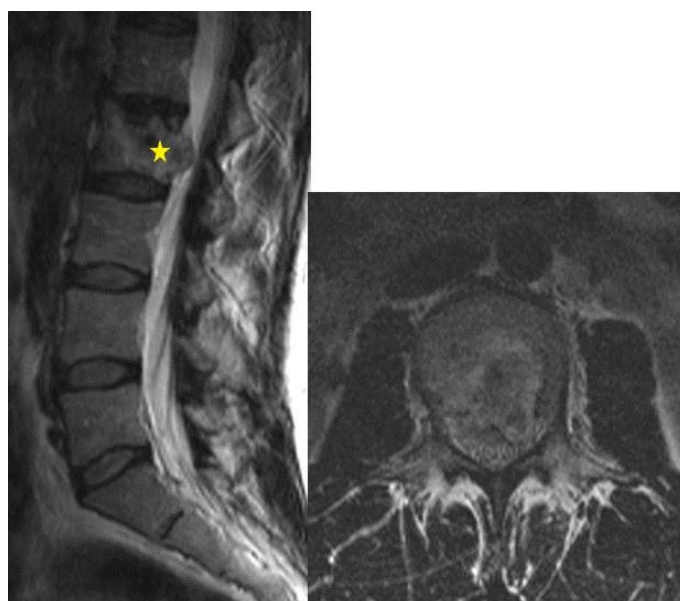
Preoperative mid-sagittal and axial MRI on T2-sequence showed an expansive tumoral lesion arising from the L2 vertebral body with epidural extension and displacement of the epidural sac.
